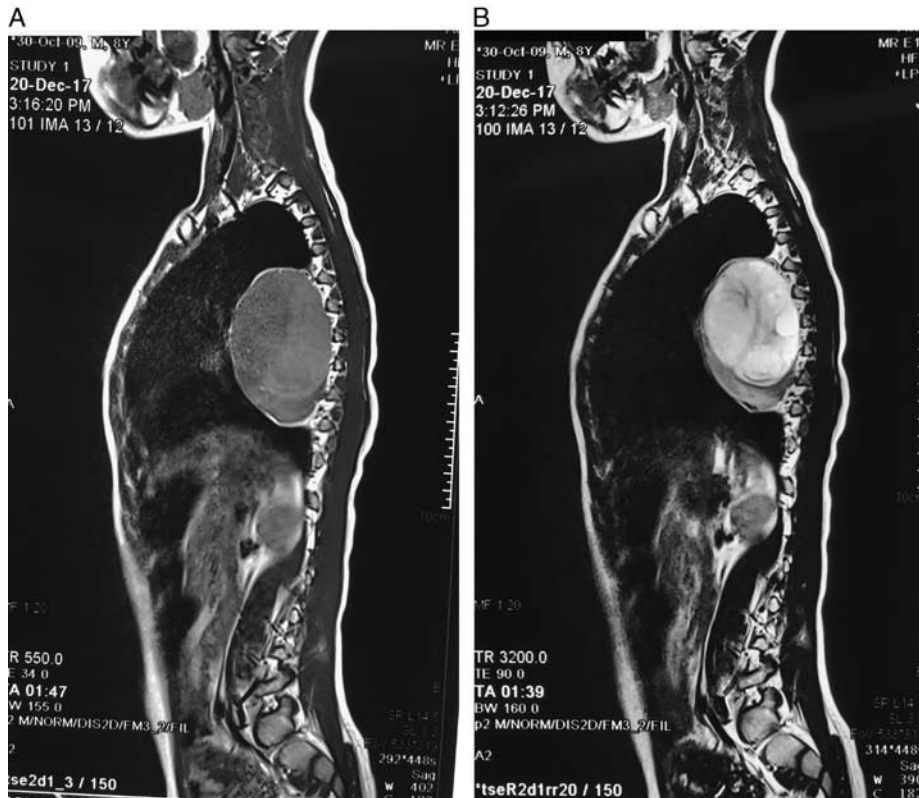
A, Magnetic resonance imaging of thorax (T1-weighted image) shows heterogenous low signal intensity. B, T2-weighted image shows a heterogenous hyperintense lesion with multiple septations within. No evidence of extension showed into the spinal canal or neural foramina.
